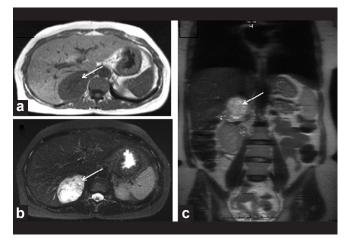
Pheochromocytoma: The mass is hypointense (arrow) on (a) axial T1-weighted image. The mass shows bright signal – "light bulb sign" (arrow) on (b) T2 axial and (c) coronal mages
